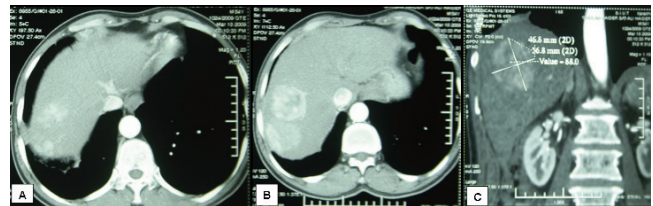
CT axial images and reconstructed coronal image showing enhancing mass lesion in segment VIII. Note the diaphragmatic margin irregularity and basal atelectasis.
